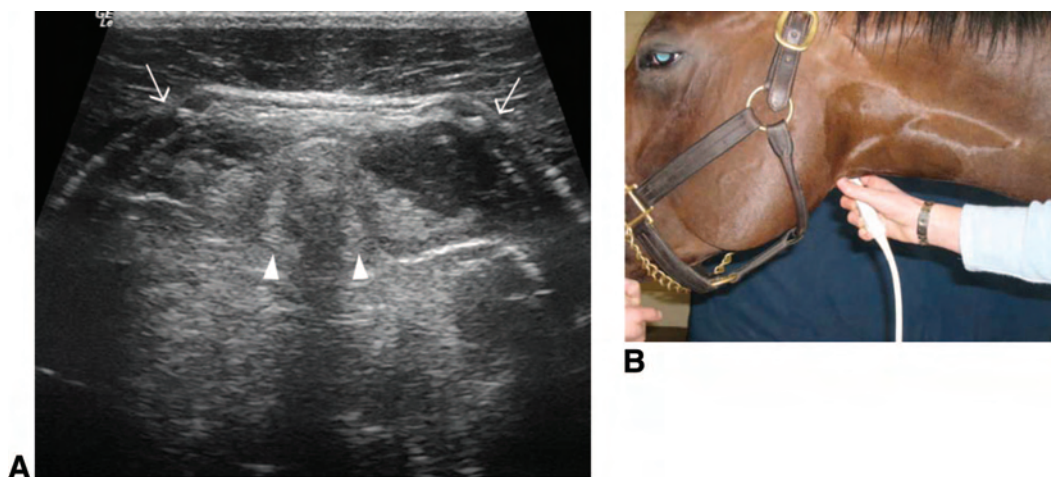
Transverse plane ultrasound image (A) of the ventral aspect of the thyroid cartilage (arrows) of a normal larynx at the level of the vocal folds (arrowheads). Transducer position is shown in B. The movement of the vocal folds can be observed during respiration. Left is to the left of the image and right is to the right of the image.
